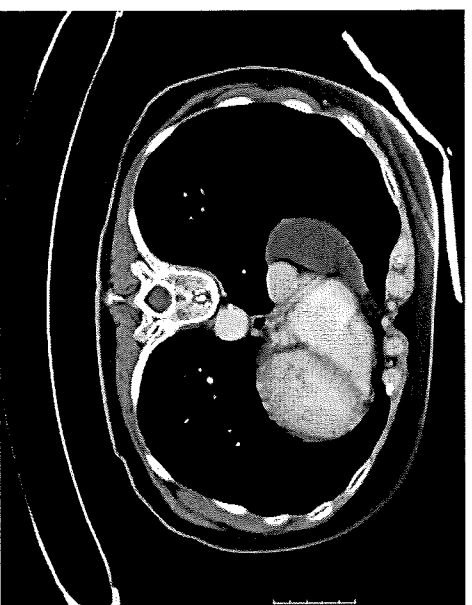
Chest computed tomography scan showing a right, cardiophrenic, 7.3-cm, soft-tissue, cystic mass.
